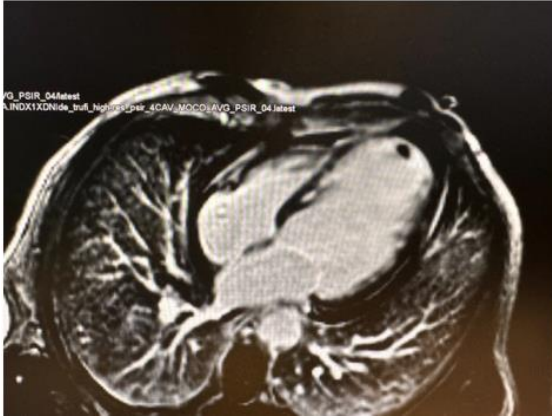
Cardiac MRI showing apical thrombus in 2 cavities and 4 cavities in the late enhancement sequence
